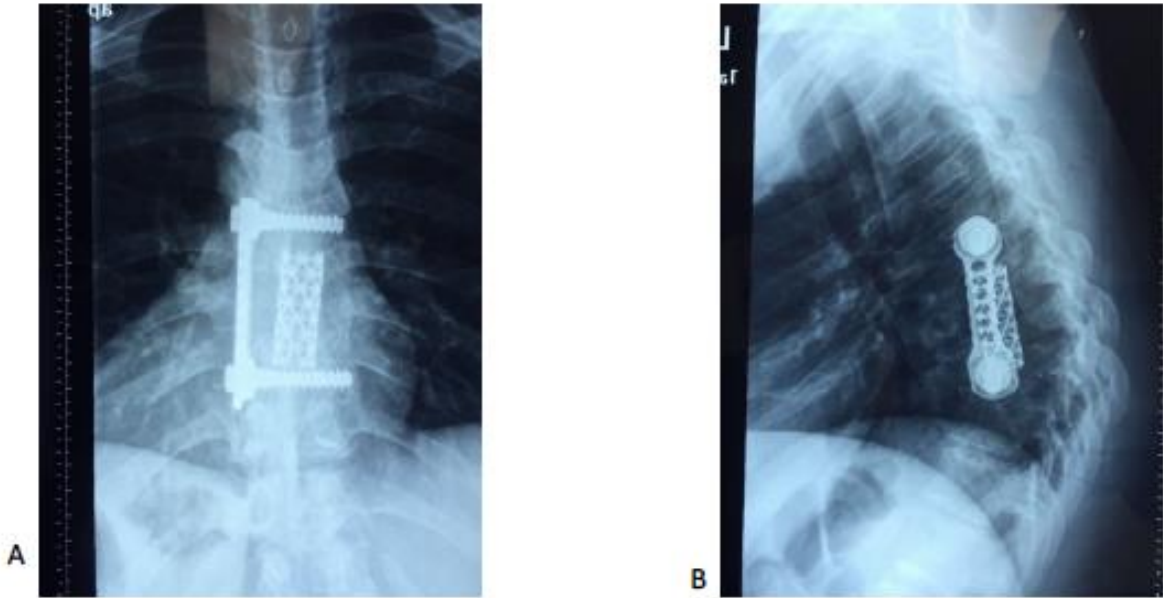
(A) and (B): Post-operative Plain X-Rays showing the construct in a patient with residual kyphosis with Medtronic implants.
